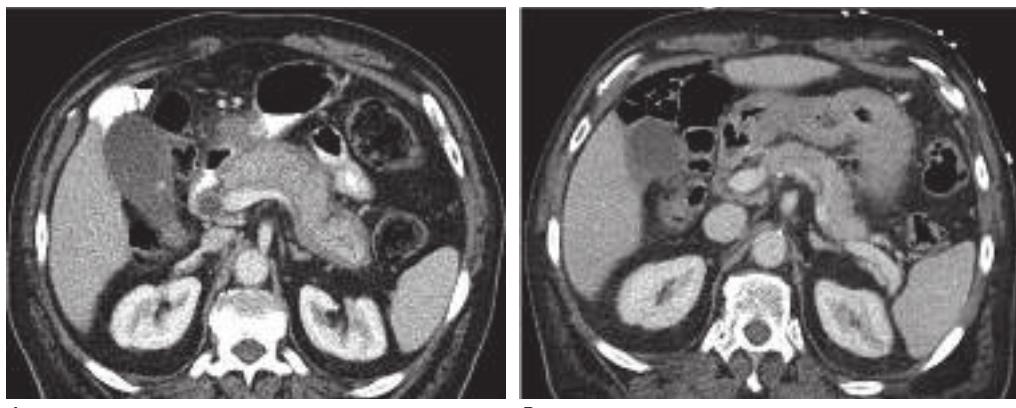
Imaging features of the pancreatic parenchyma in a patient with type 1 autoimmune pancreatitis on computed tomography (CT). *A*, Contrast-enhanced CT scan of the abdomen demonstrates diffuse pancreatic enlargement and a hypodense rim (capsule sign) in a patient who presented with jaundice. The serum IgG4 level was elevated to 942 mg/dL (reference range 4–86 mg/dL), so the patient was diagnosed with definitive type 1 autoimmune pancreatitis. *B*, Contrast-enhanced CT scan of the abdomen following a treatment course with high-dose steroids demonstrates return to normal size of the pancreas, reappearance of normal lobulations along the margin, and absence of the hypodense rim.
